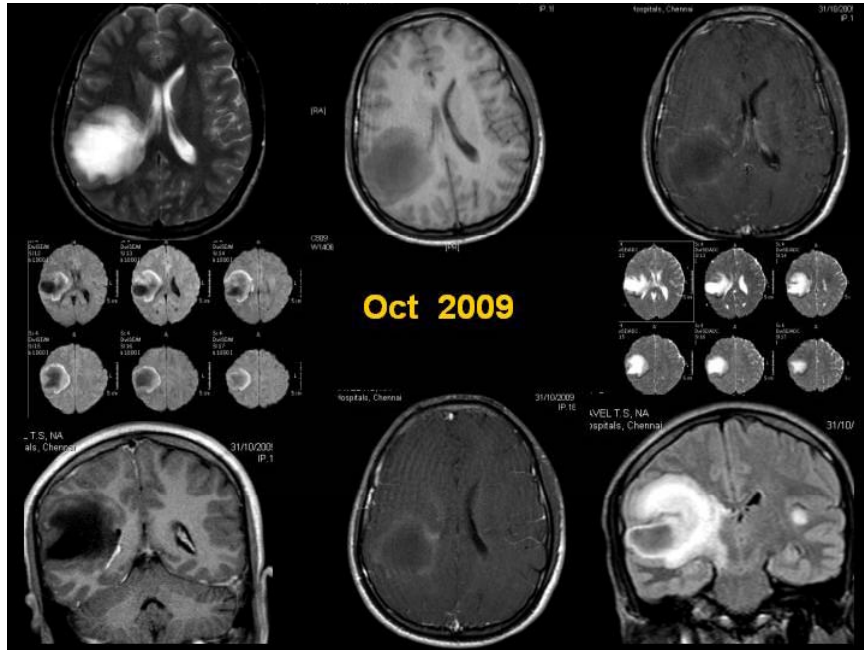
MRI shows a large, peripherally faint, indistinct enhancing lesion with perilesional edema and mass effect in the right temporal lobe; lesion reveals a peripheral rim of restricted diffusion on DW images suggesting a neoplasm
